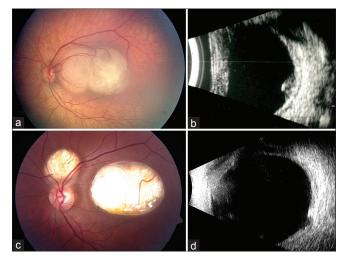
Neonatal retinoblastoma managed in the pre-chemotherapy era. (a) Large macular retinoblastoma in a 25-day-old female. (b) Ultrasonography showed echodense, calcified retinal mass with orbital shadowing. (c) Following external beam radiotherapy, recurrence necessitated enucleation. (d) At 27-year follow-up, there was orbital bone hypoplasia, more significant on the right side
